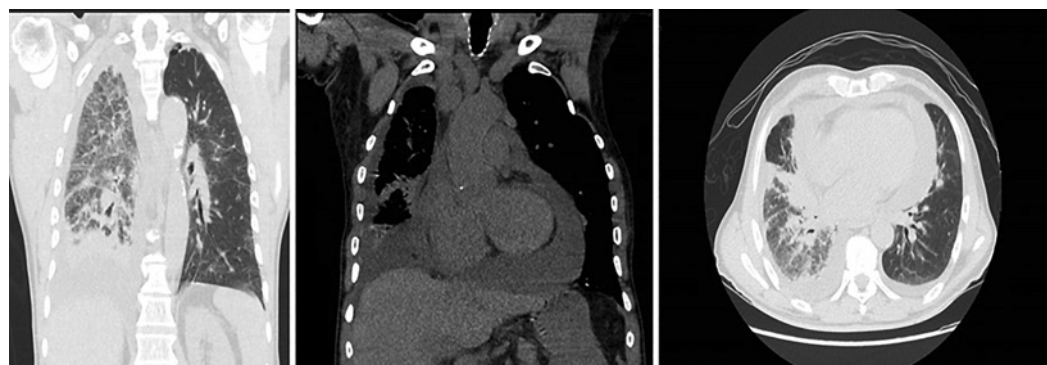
Sagittal and coronal view of the CT chest without contrast demonstrated moderate to large PerF, right pleural effusion, and a posteriorly layering component with multiple lymphadenopathies.
